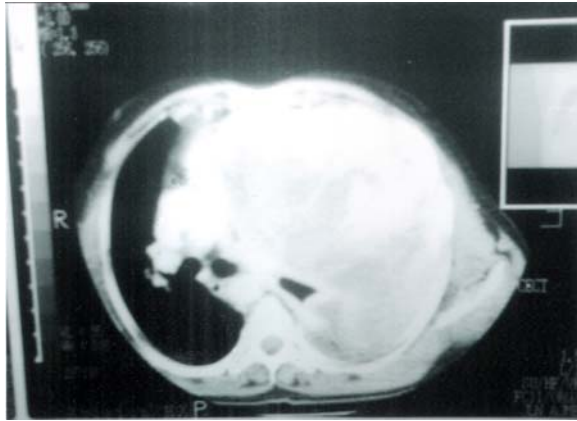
CT thorax showing a huge solid to cystic, well circumscribed mass with calcified areas, involving whole of the left thorax and mediastinum.
